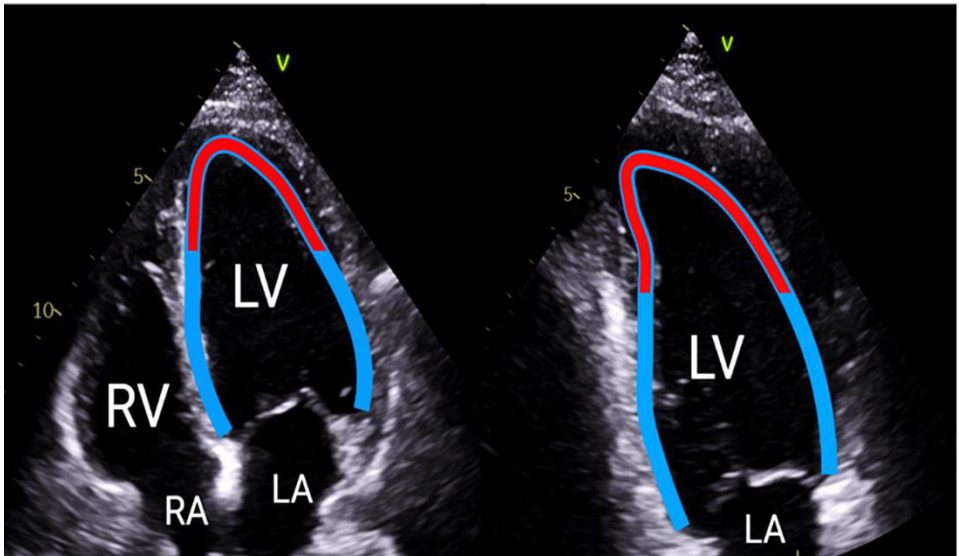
Assessment of akinesia in apical four- (left) and two-chamber (right) views. The LV endocardial length was measured in diastole (blue line), and the extent of akinetic myocardium was outlined and measured (red line). Total akinesia was expressed as the percentage of akinetic length relative to total ventricular length across both views. RA, right atrium; RV, right ventricle; LV, left ventricle; LA, left atrium. Created with BioRender.com.
